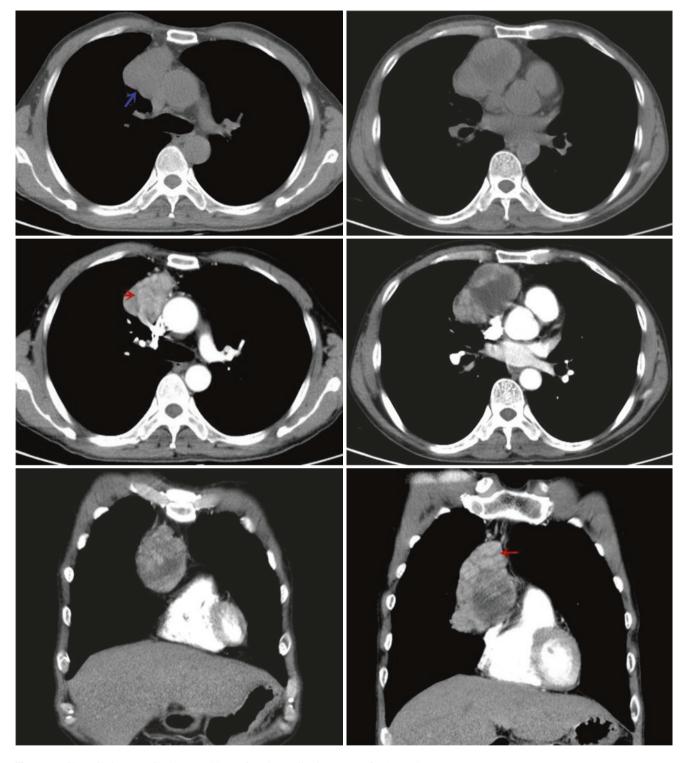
Chest CT images of a 51-year-old man found a mediastinum mass for 1 month
